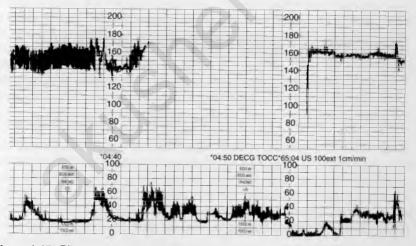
Effect on variability of changing monitoring mode from fetal electrode to ultrasound in a machine with autocorrelation facility.
